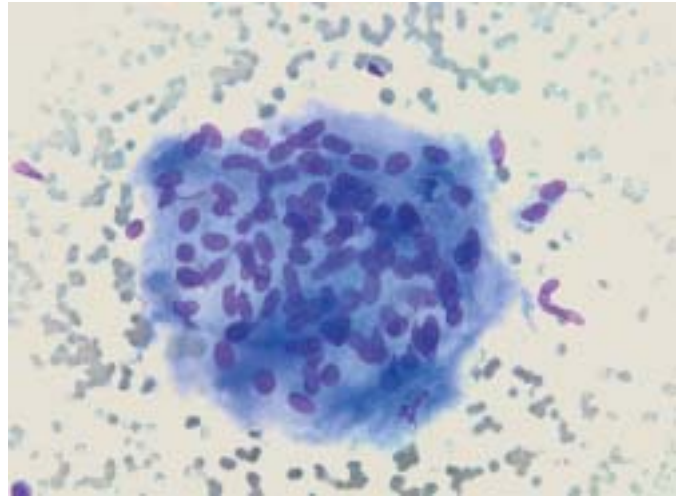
Endoscopic ultrasound-obtained lymph node aspirate demonstrating a noncaseating granuloma without necrosis, as seen in sarcoidosis.
